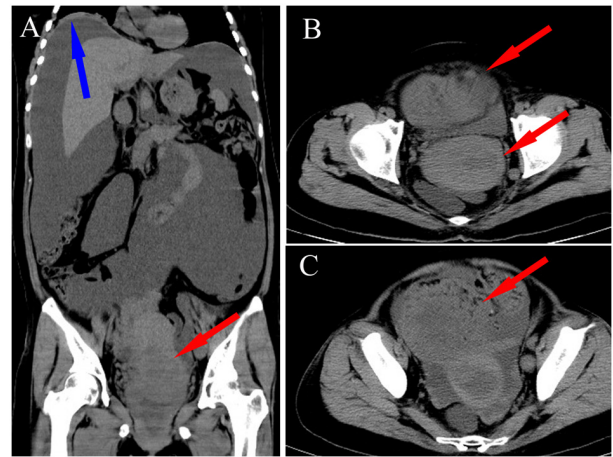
CT findings upon hospital admission. (A) CT coronal image showing marked abdominal distension in the patient, with a significant amount of ascites causing elevation of the diaphragm (blue arrow) and a massive cervical tumor (red arrow). (B) A roughly round, heterogeneously dense mass measuring ~6.1x5.6 cm is observed within the cervix (arrow), with unclear boundaries. (C) Patchy and nodular shadows are seen adjacent to the right side of the uterine body and in the lower abdominal cavity, with the larger shadow measuring ~4.5x4.1 cm. The greater omentum (arrow) is thickened and folded into a pancake shape. CT, computed tomography.
